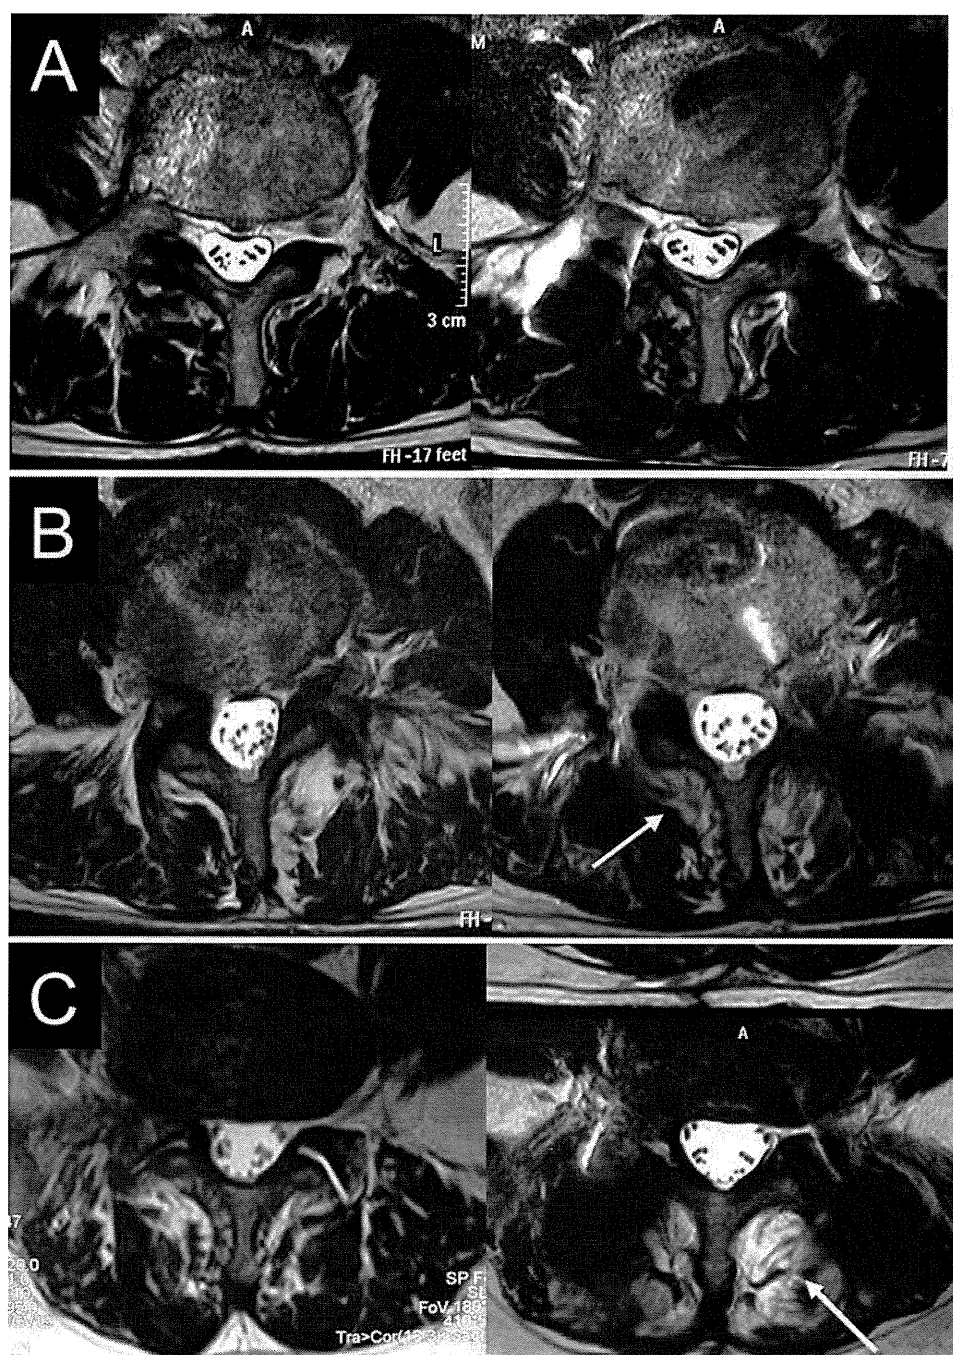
Magnetic resonance imaging grades of paravertebral muscle injury. Preoperative images are shown on the left and postoperative images on the right. A: Typical case of Grade 0 with no signal change in the multifidus muscle. B: Typical case of Grade 1 with signal change in less than 50% of the cross-sectional area of the multifidus. The *arrow* indicates muscle degenerative changes in the deep layer of the muscle. C: Typical case of Grade 2 with signal change in more than 50% of the multifidus area. The *arrow* indicates muscle degenerative changes in the multifidus muscle.
